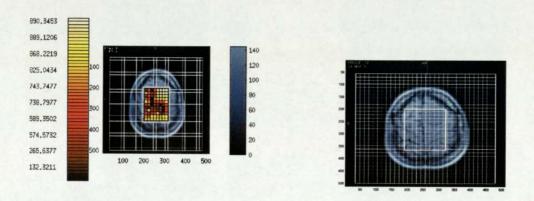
Gadolinium-enhanced MRI scan for a meningioma patient with and without NeuroScale distances mapped on top (Euclidean distance).
